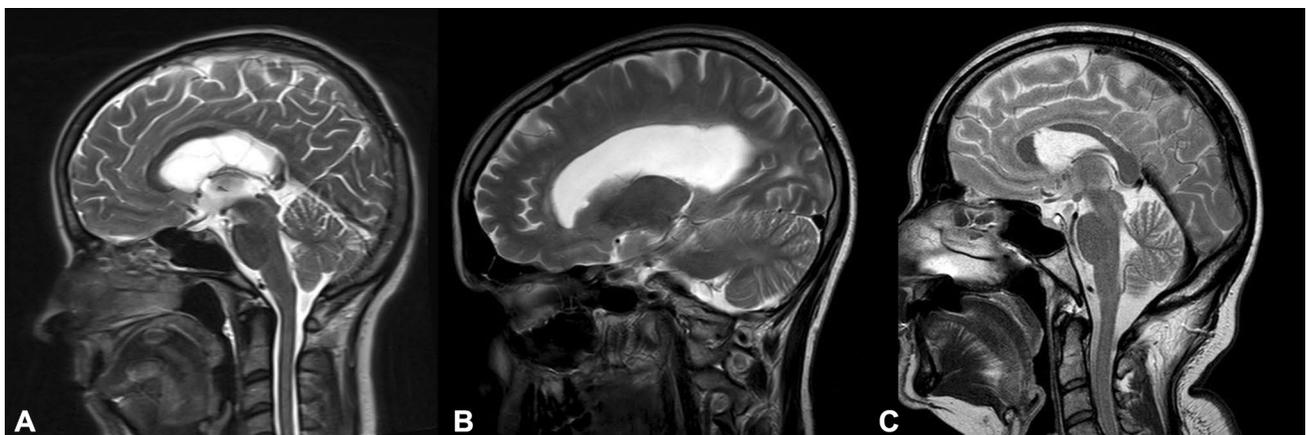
MRI of the brain with abnormalities of corpus callosum in three different patients
